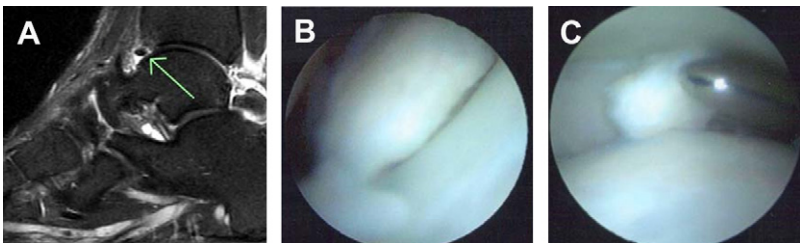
Meniscoid lesion. (A) Sagittal T2 MRI demonstrating anterior joint effusion with a loose body (*arrow*) noted on the anterior lip of the tibia. Joint effusion with increased signal intensity is noted around os trigonum. (B) Arthroscopic image reveals meniscoid lesion. (C) After partial resection with probe demonstrating no associated articular damage.
